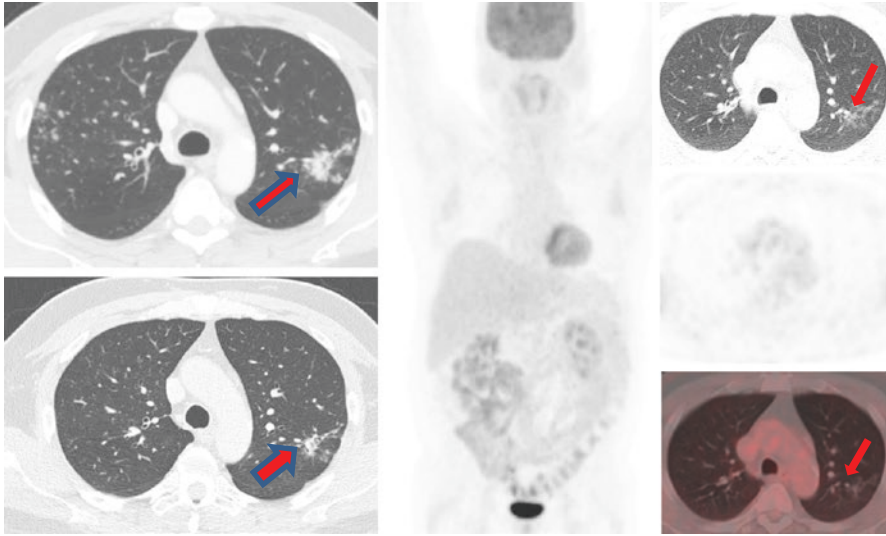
FDG PET CT to assess response to treatment in a case of multi-drug resistant (MDR) TB: MDR TB on sputum culture with confluent nodularity in the left upper lobe and tree in bud nodularity in both upper lobes. CT at 4 months (upper left image) and 18 months (lower left image) post-treatment show progressive response on CT. The residual left upper lobe changes on CT are FDG negative on PET CT at 18 months, suggesting a complete metabolic response. (Image courtesy Dr Tara Barwick, Consultant Radiologist, Imperial College NHS Healthcare Trust UK)
